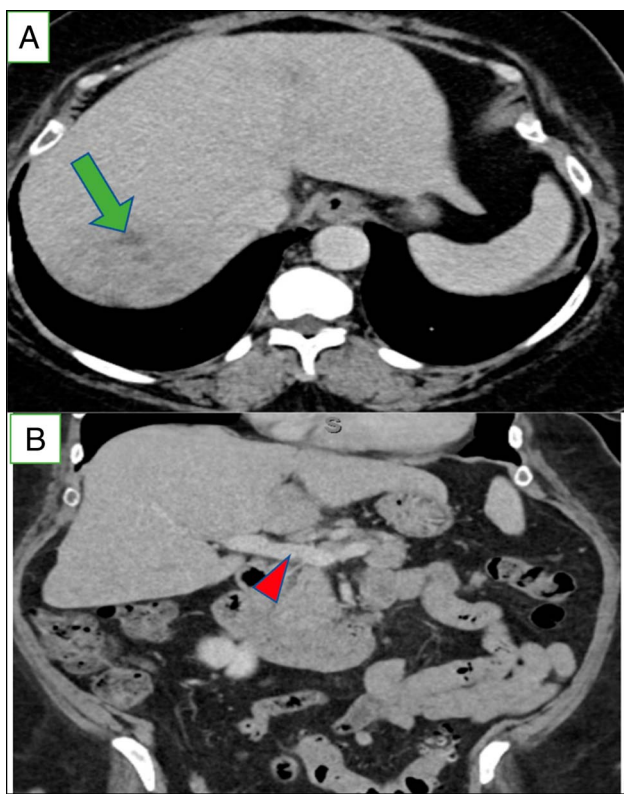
Repeat abdominal and pelvic computed tomography with intravenous contrast after 12 weeks showing (A) near-complete resolution of hepatic abscess on the right lobe (green arrow) and complete resolution of hepatic abscess on the left lobe and (B) near-complete resolution of thrombus in the portal vein (red arrow head).
